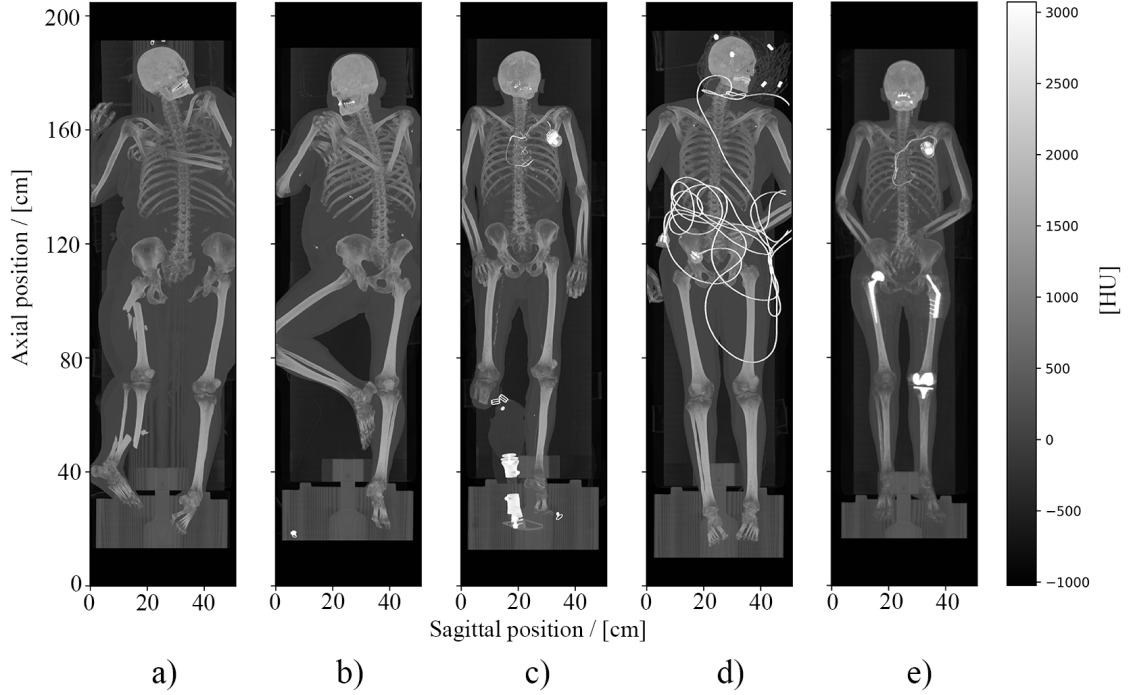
Coronal MIPs generated from the triage CT scans of representative cases found in forensic databases. a) High-force fracture. b) Limb outside of FoV. c) Missing limb. d) Foreign objects. e) Metallic implants.
